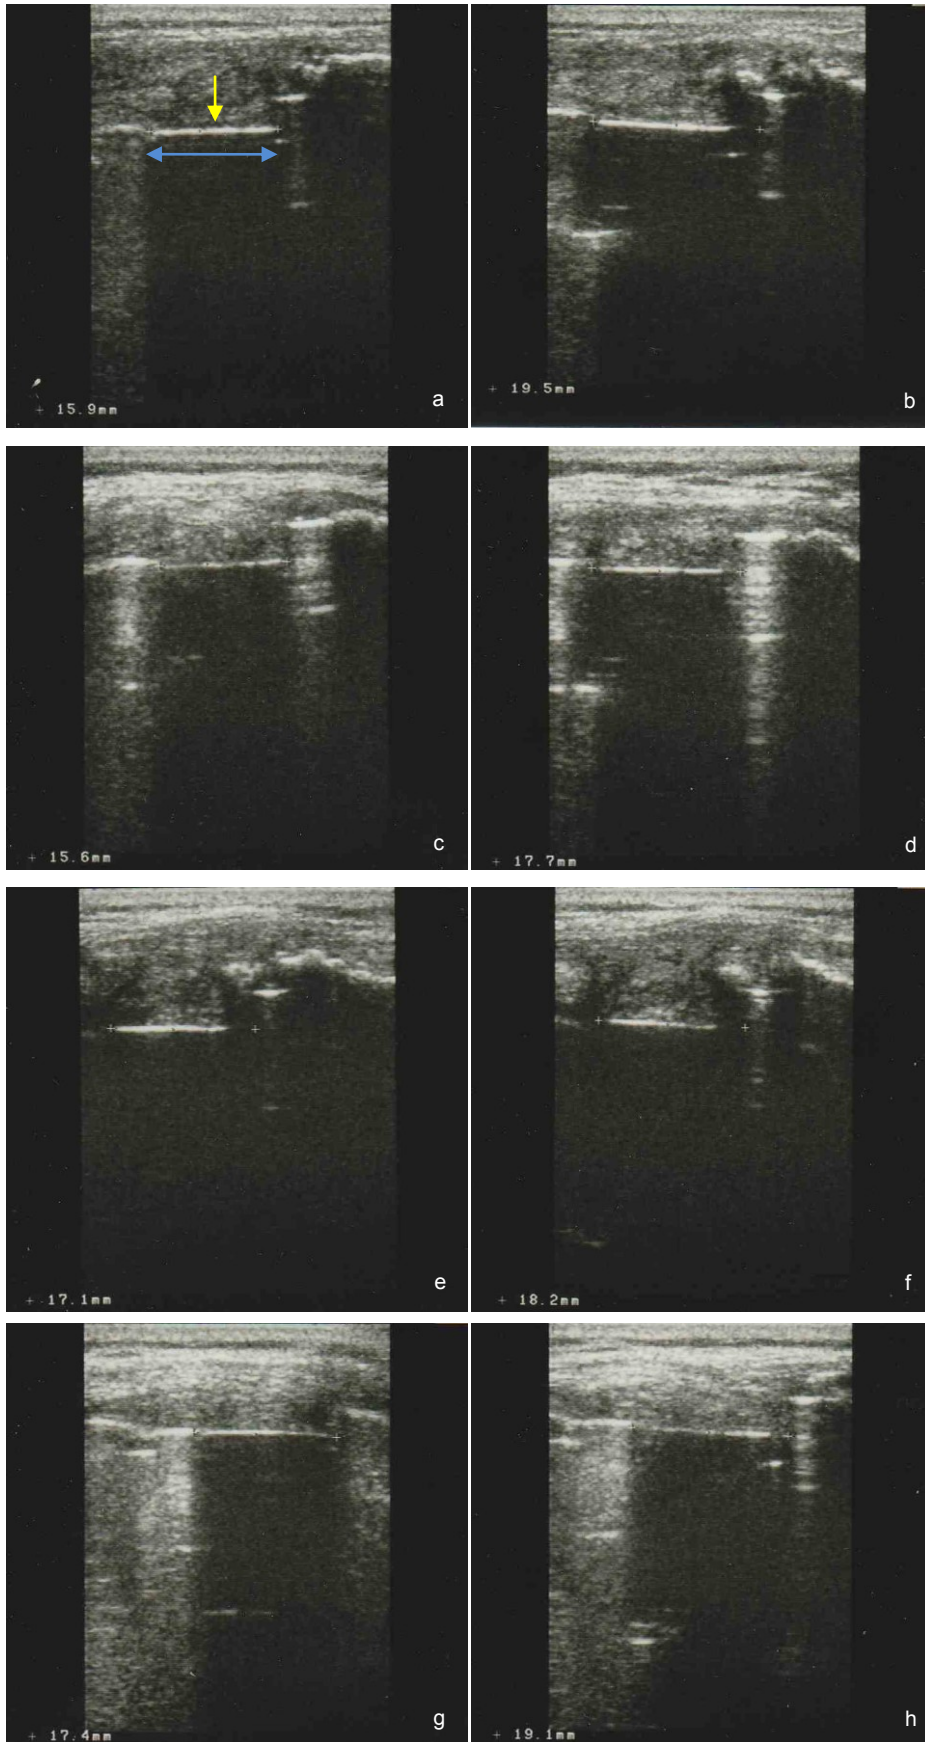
Ultrasonography of the knee of a 28-years old patient after distal femoral replacement due to a chondrosarcoma G2. a-b) lat. extension with & without varus stress, c+d) med. extension with & without valgus stress, e+f) lat. flexion with & without varus stress, g+h) med. flexion with & without valgus stress.
